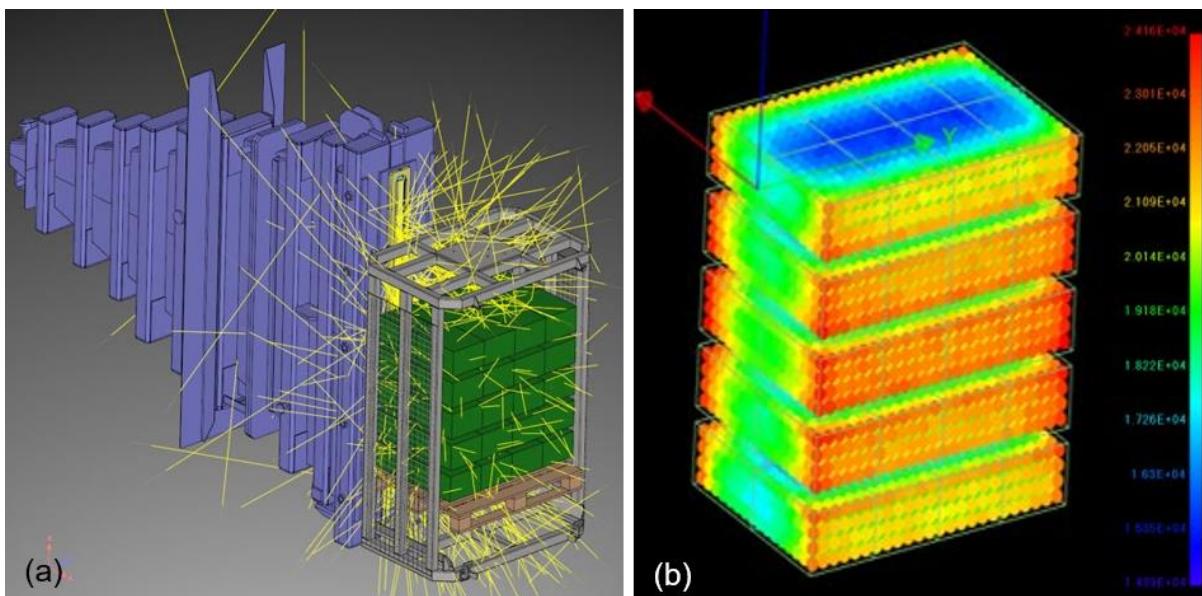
(a) Visualisation by RayXpert of an X-ray scanner irradiating a product pallet. (b) Graphic representation by RayXpert of dose distribution in a product pallet.
